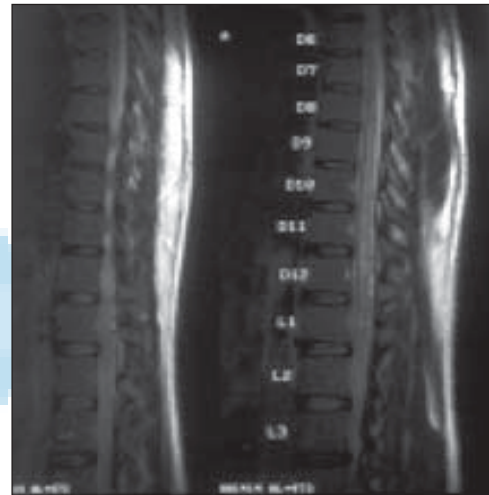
MRI lumbar region T2 W sagittal showing dilated tortuous epidural vein, cord changes
